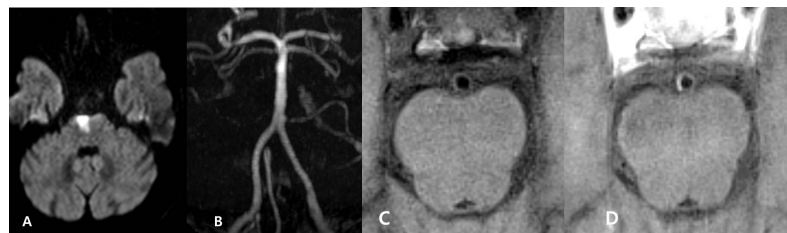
DWI image (A) shows an acute infarcted lesion at the right basis pontis.. TOF-MRA (B) shows no evidence of stenosis at the basilar artery. Precontrast 3D Black-Blood image (C) reveals no atherosclerotic change at the basilar artery. Postcontrast 3D Black-Blood image (D) visualizes mild eccentric vessel wall enhancement at the right mid-basilar artery.
